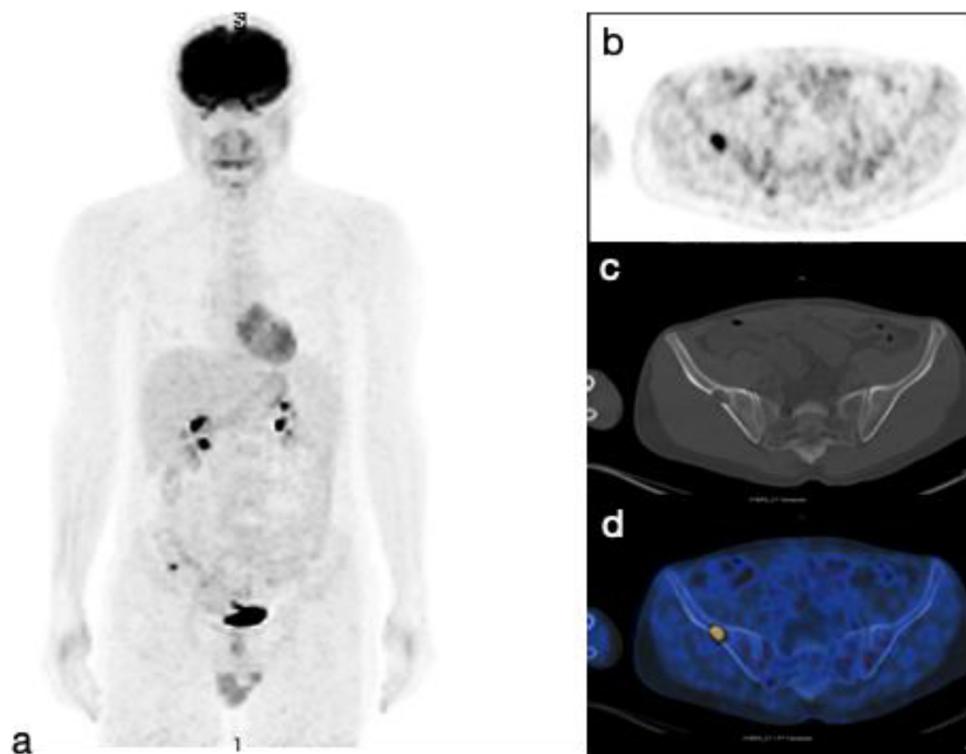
FDG PET-CT images showed increased uptake in the solitary osteolytic lesion in right iliac bone (a: Maximum intensity projection images (MIP), b-d: FDG PET, CT and fusion images).
